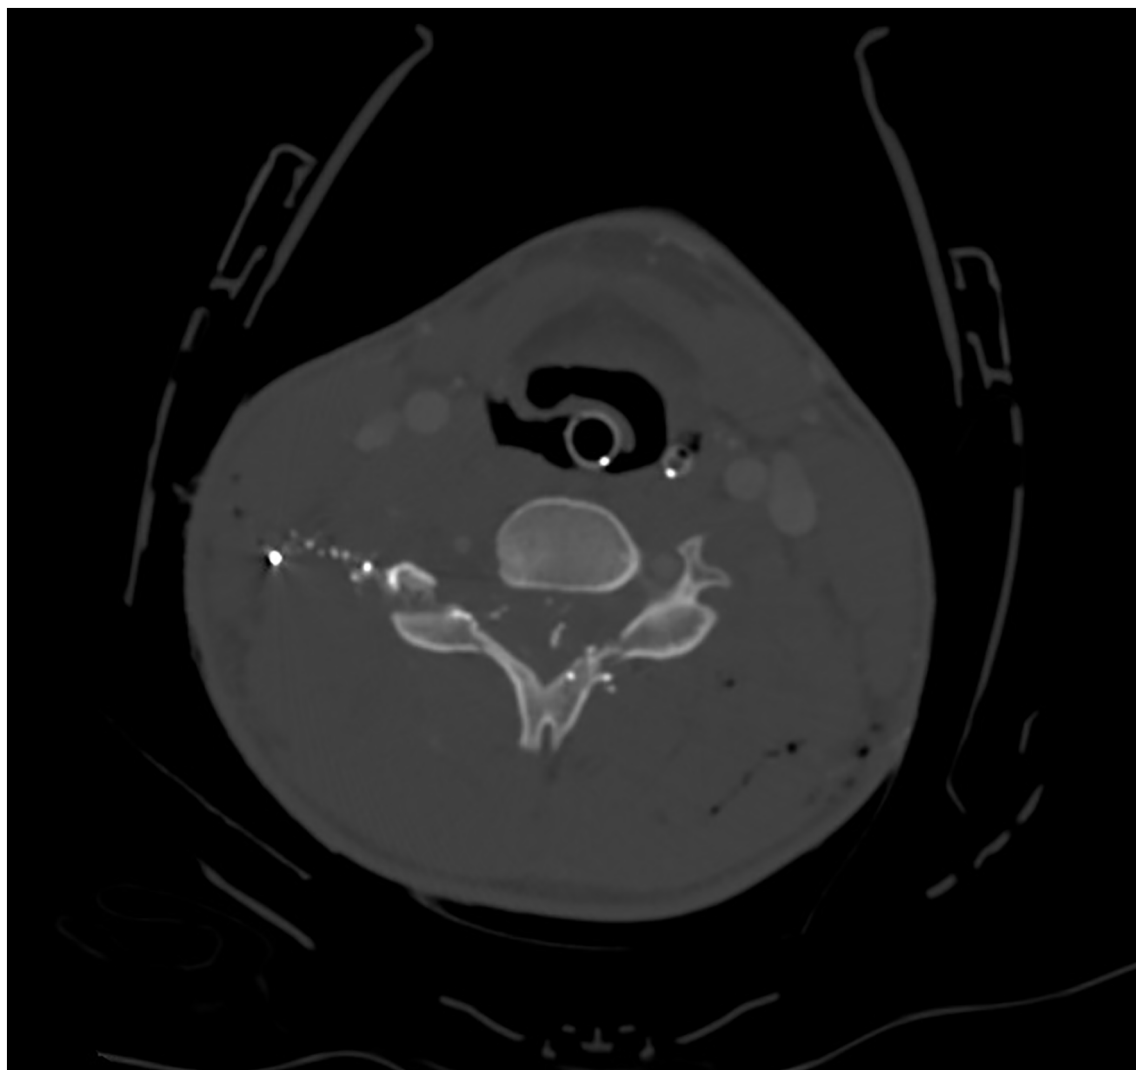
Cervical spinal cord computed tomography image of Patient 003.
